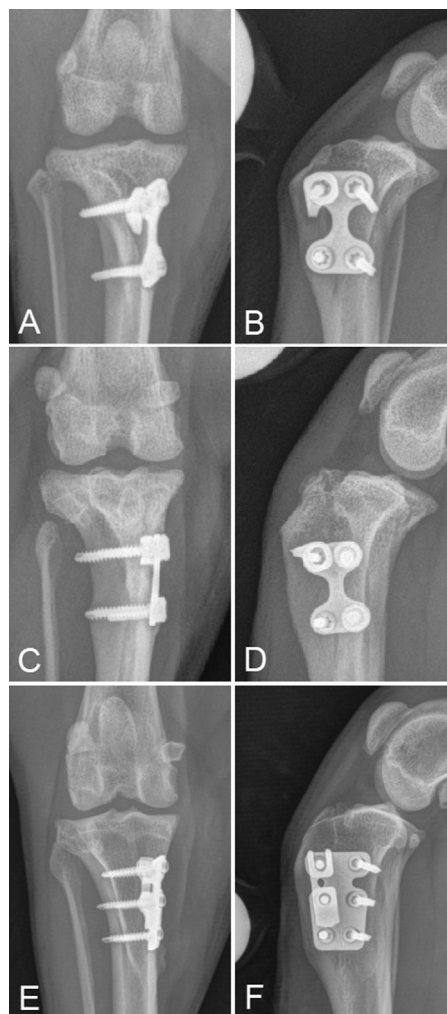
Craniocaudal and mediolateral radiographs taken 6 weeks postoperation, showing (A–D) two cases in which the distal half of the spacer was removed and (E,F) a case in which a two-hole spacer was used instead of a three-hole spacer, to facilitate placement of the spacer between the tibial crest and plate.
